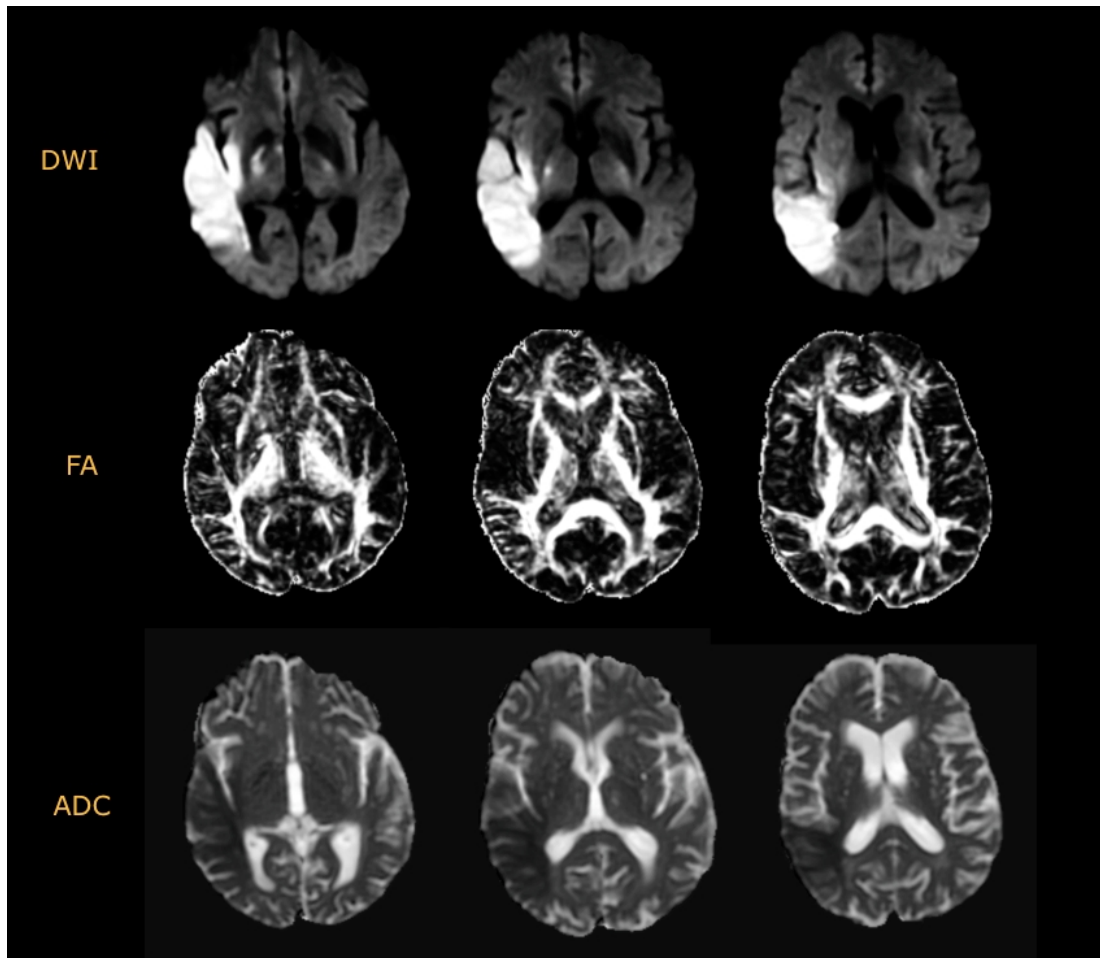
Axial slices for a patient with acute ischemic stroke using diffusion-weighted imaging (top row), fractional anisotropy map (middle row) and apparent diffusion coefficient map (bottom row). The lesion is more visible on DWI (bright area) and ADC images (dark area) than FA map.
